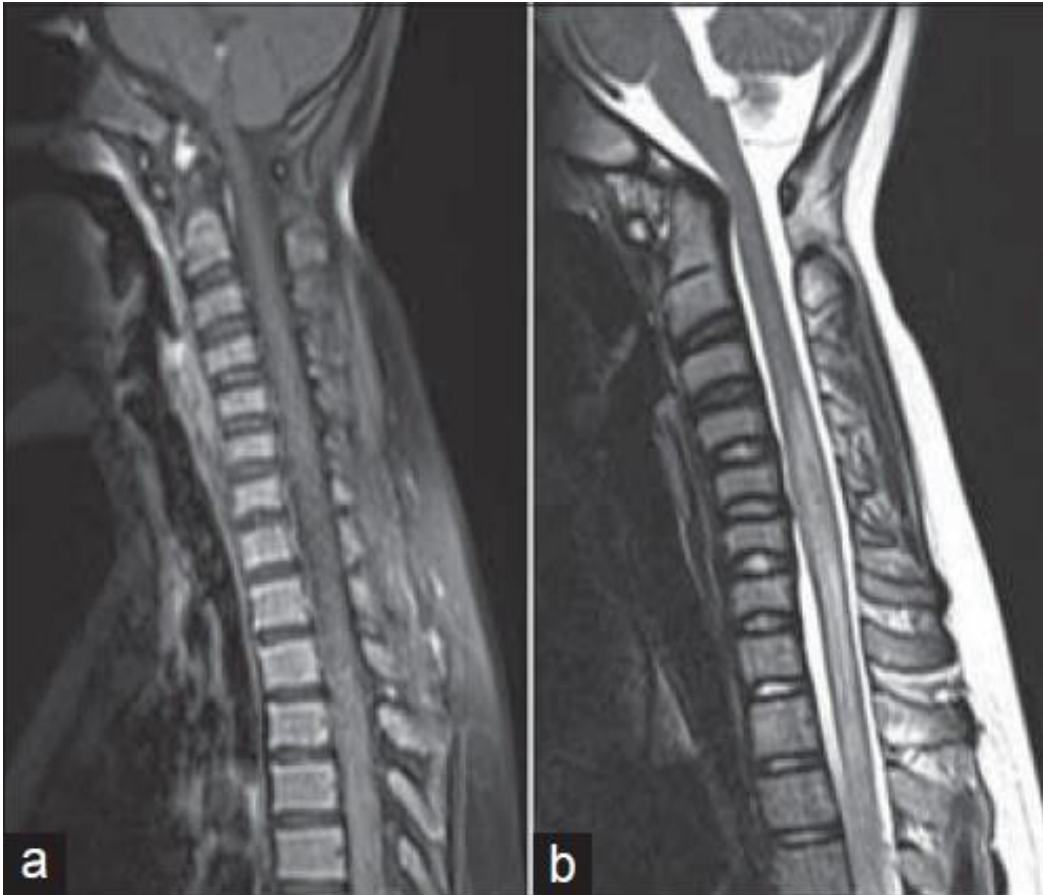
Magnetic resonance imaging of spinal cord (sagittal view) showing normal spinal cord in T1-weighted image (a) and hyperintensity within the cord adjoining C-5 to D-4 vertebrae in T2-weighted image (b), suggesting long segment acute transverse myelitis.
